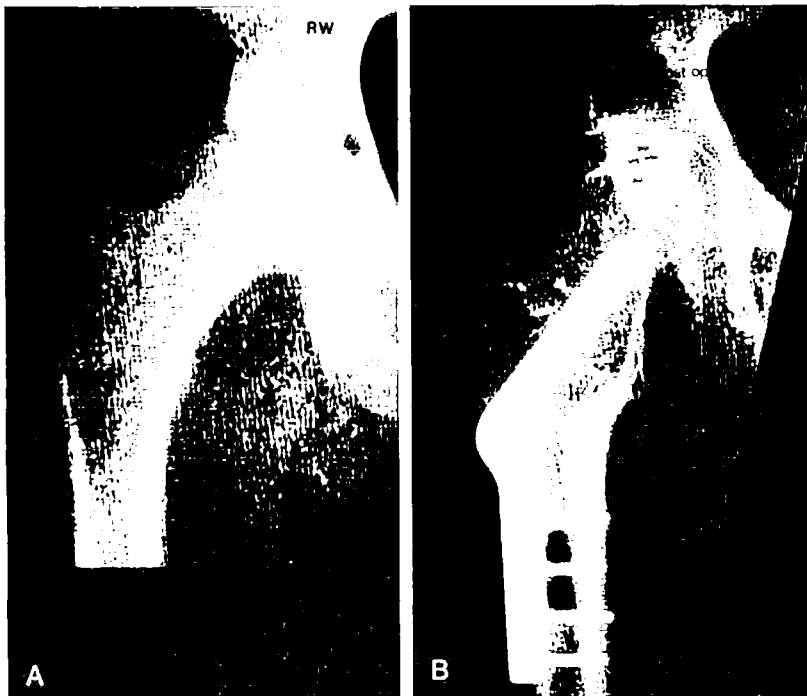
AP radiographs preoperatively (A) and postoperatively (B) of a hip with osteonecrosis treated with a valgus/extension osteotomy. (Courtesy of T. Thornhill, MD, Boston, MA.)
